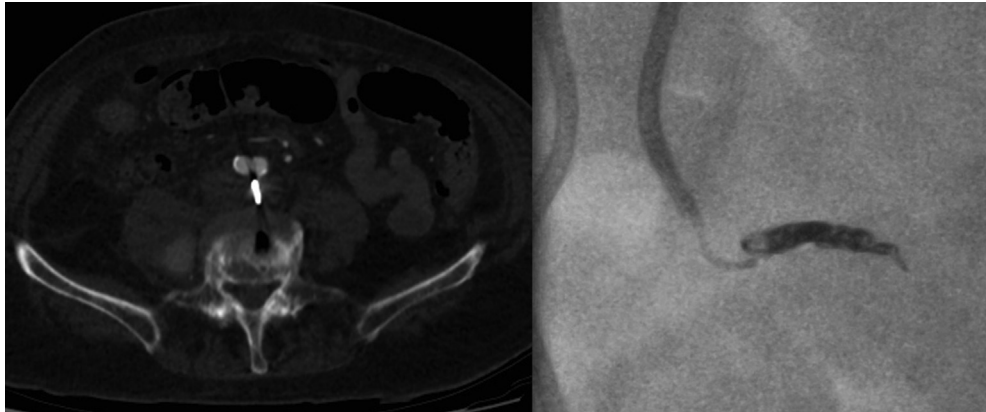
Postoperative computed tomography angiography and digital subtraction angiography images showing the coils in the sacral artery occluding inflow to the pseudoaneurysm.
